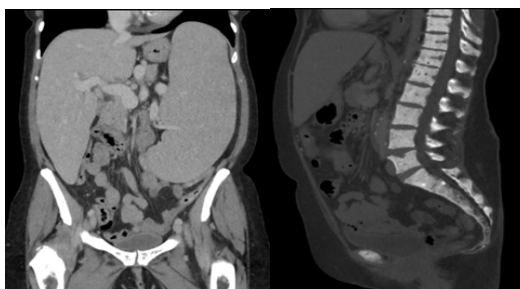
CT of the abdomen with contrast, coronal (a) and sagittal (b) views, reveals massive hepatosplenomegaly (a) and diffuse osteosclerosis of the vertebral bodies (b).
